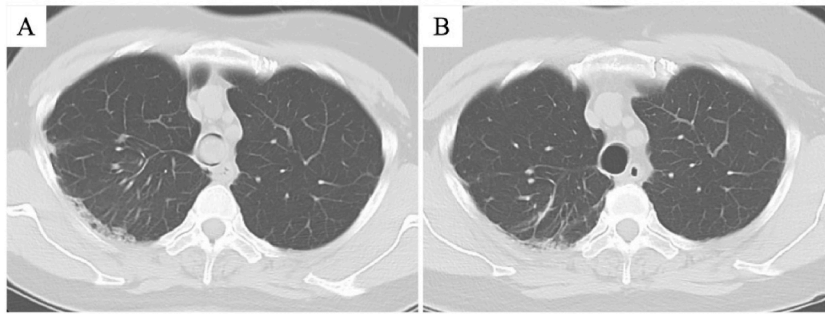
Computed tomography (CT) shows severe tracheal obstruction due to a tumor on admission (A). CT showing no recurrence after 7 years post-resection (B).
